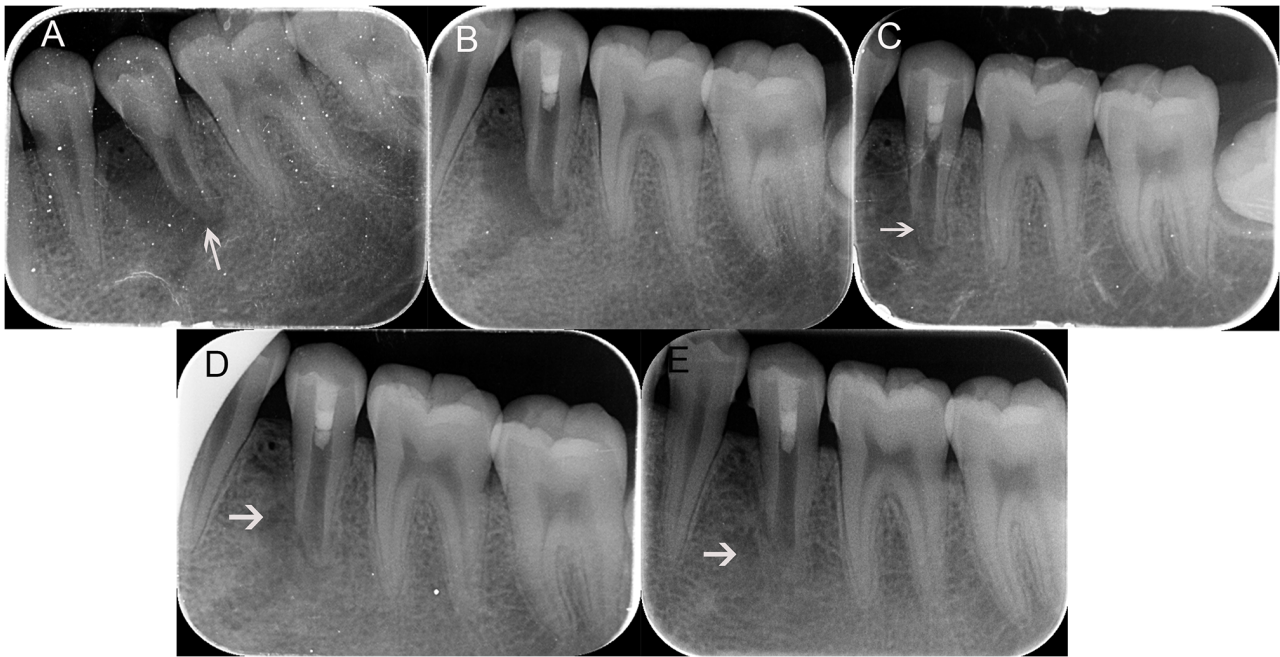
Periapical radiographs of case 2. (A) Preoperative radiograph of tooth 20. An extensive radiolucent area at the mesial aspect of the root and an oblique inflammatory resorption resulted in an open apical foramen, thin canal walls and an anomalous configuration of the root apex (white arrows). (B) Postoperative radiograph of tooth 20 immediately after RET. (C) Periapical radiograph obtained at the 3-month follow-up. Slight mineral deposition was observed at the mesial root canal wall and apical area compared with the postoperative radiograph, as indicated by a white arrow. (D) Periapical radiograph obtained at the 6-month follow-up. There was an obvious increase in radiographic alveolar bone density and a decrease in the radiolucent area along the mesial side of root (white arrows). (E) Periapical radiograph obtained at the 36-month follow-up. The alveolar bone density of the periapical lesion at the mesial side of the root was almost identical to that of normal alveolar bone (white arrows). RET, regenerative endodontic treatment.
